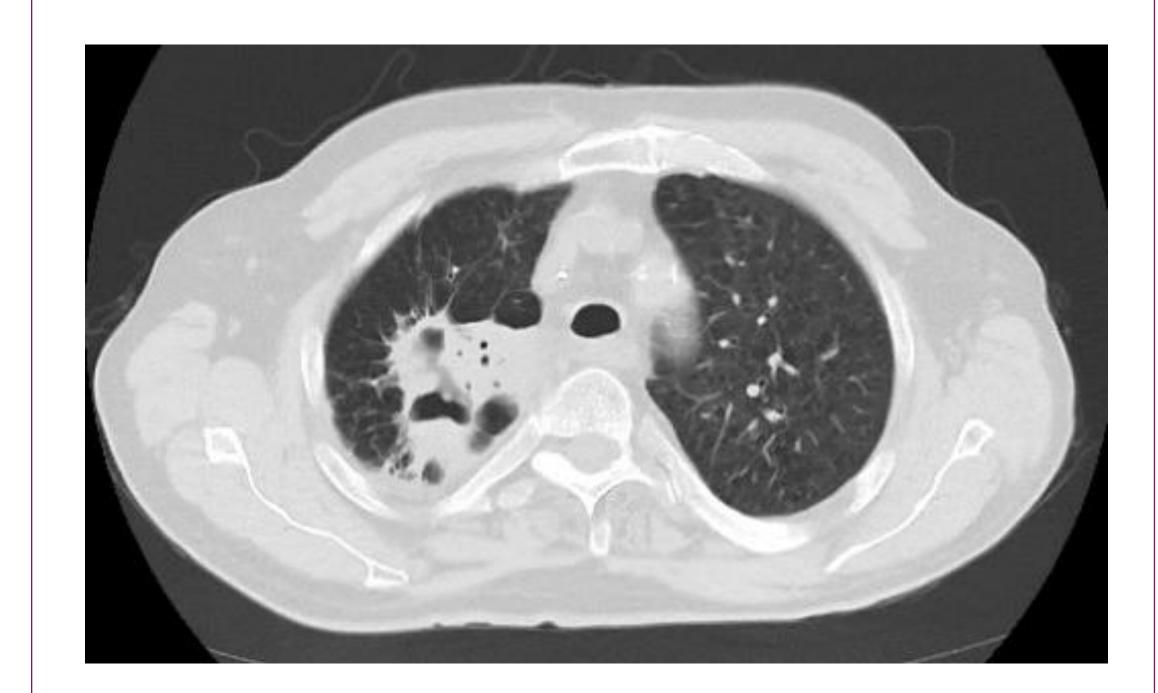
CT Chest 9/30/21
